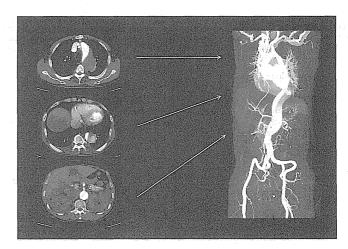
Contrast-enhanced cardiac vascular computed tomography showed dissecting aortic aneurysm of the aortic arch and the descending aorta.
